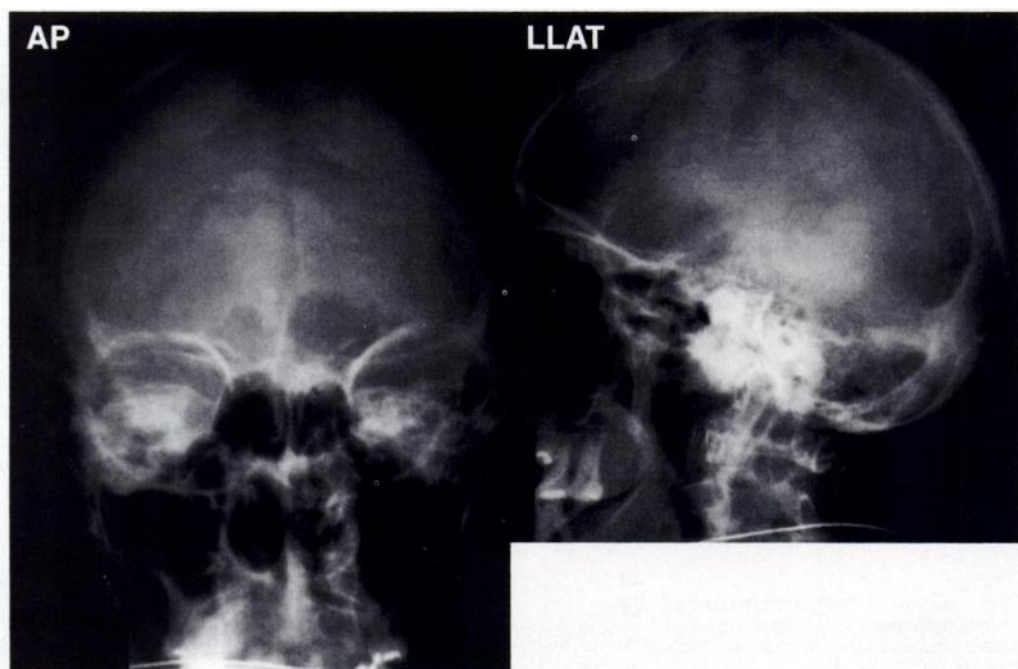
Anteroposterior and left lateral skull radiographs demonstrate the nodular, sclerotic, thickening of the inner table of the frontal bones with sparing of the outer table, characteristic findings in hyperostosis frontalis interna. The radiographic changes, in contrast to the radionuclide changes, are symmetric in appearance.
